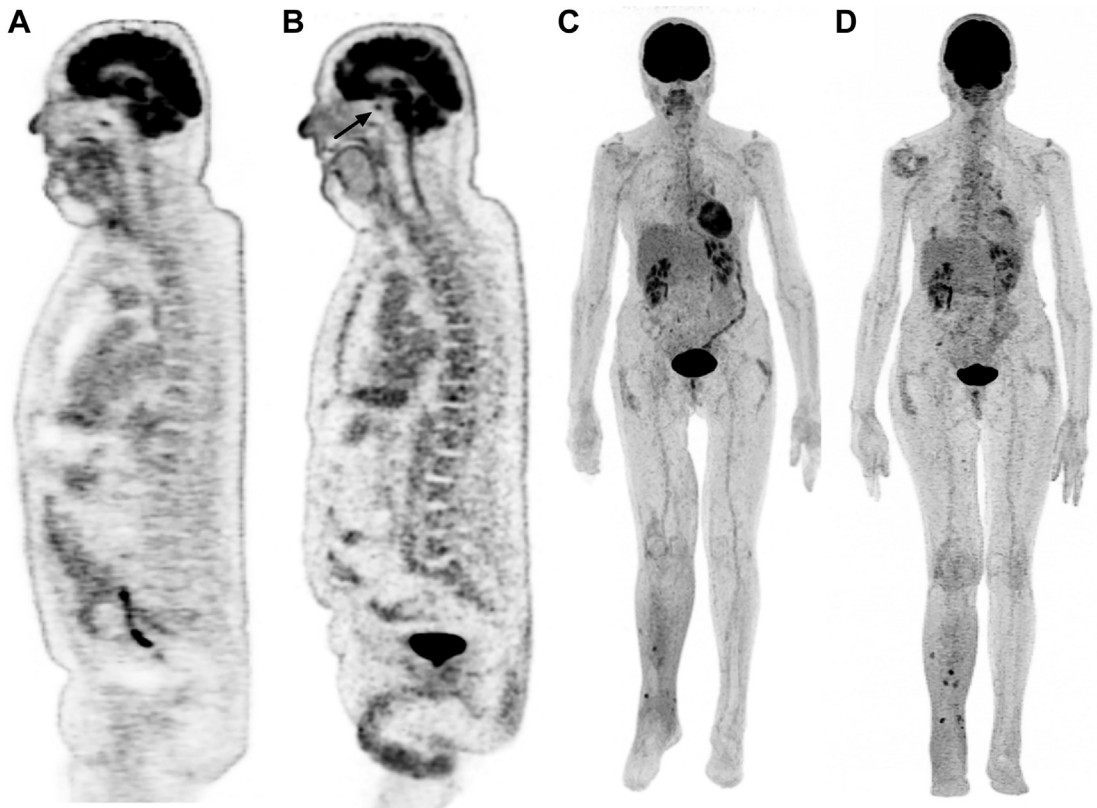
PET protocol. Serial sagittal ^{18}F FDG PET and PET-CT, including the skull in different phases of the disease in a 74-year-old man affected by a metastatic melanoma of the right thigh. (A) Baseline before introduction of immunotherapy and (B) after 6 courses of nivolumab, showing a related hypermetabolism in the pituitary gland (arrow) owing to nivolumab toxicity in an asymptomatic patient. Serial ^{18}F FDG maximum intensity projection (MIP), including the skull and lower limbs in different phases of the disease in an 82-year-old woman affected by a melanoma of the right ankle with in transit metastases of the right lower limb and the lung. (C) Baseline before introduction of immunotherapy and (D) after 2 courses of nivolumab, showing a metabolic progression in the right lower limb and lung.
